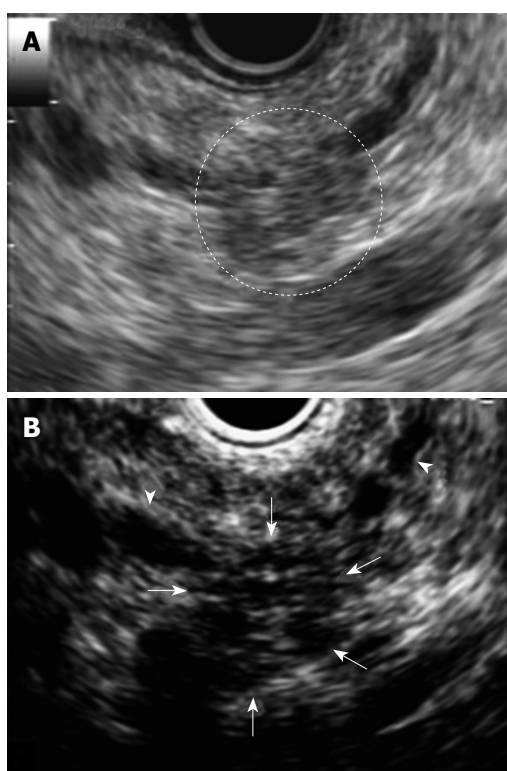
Endoscopic ultrasonography (EUS) at two years later examination showing pancreatic tail. A: EUS showing low echoic lesion which is vague and the area had unclear margins in the pancreatic tail; B: Contrast-enhanced harmonic EUS showing a clear margin of 10 mm in diameter and hypovascular nodule compared with surrounding pancreatic tissue (arrows). MPD: Main pancreatic duct (arrowheads).
